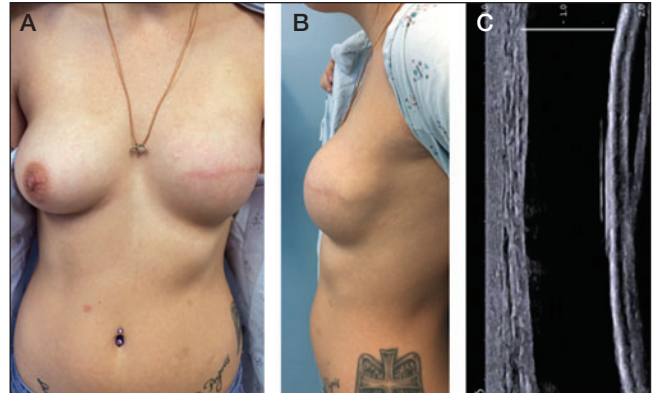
A and B Photographs taken at the time of detection of suspected device rupture. C Representative image of left breast ultrasound demonstrating periprosthetic fluid and deflated tissue expander consistent with device rupture
